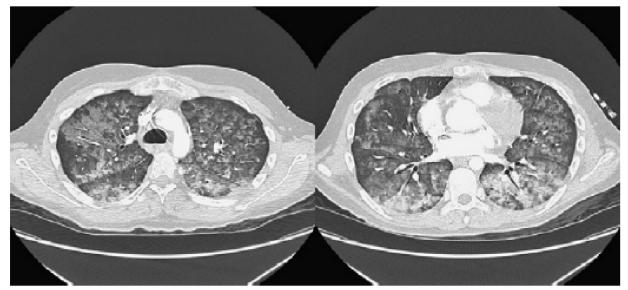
CT chest (2 slices) showing diffuse pulmonary haemorrhage
